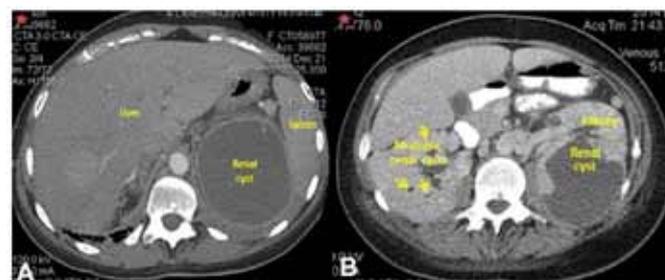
Contrast-enhanced arterial-phase computed tomography scan of the abdomen showed: (A) A sizeable cyst (14x9x8 cm) with thin wall, pressing against spleen and adjacent structures, (B) Enormous renal cyst dashed out from upper lobe of the left kidney, while multiple smaller simple cysts revealed in the right kidney.
